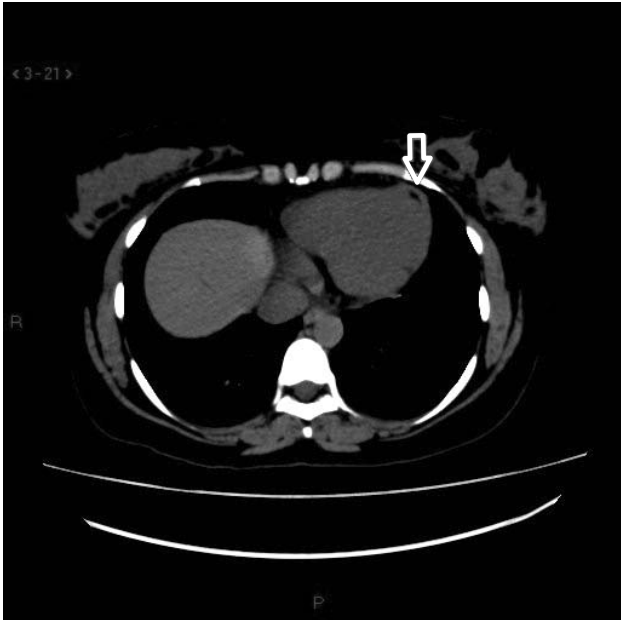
Myocardial fatty foci (MFF) on axial CT chest
